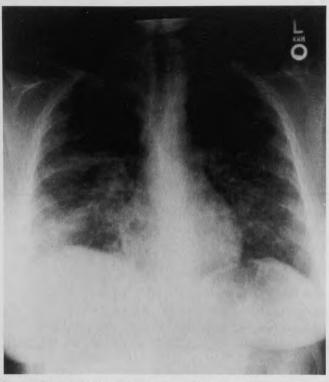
Admission posterior-anterior chest roentgenogram showing bilateral diffuse air space and interstitial infiltrates with a small right-sided pleural effusion.
